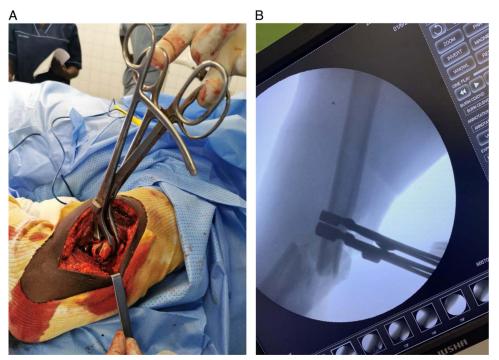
(A) Two forceps on the proximal fragment were used to reduce the shoulder dislocation; (B) radiographic control of the forceps in place.
